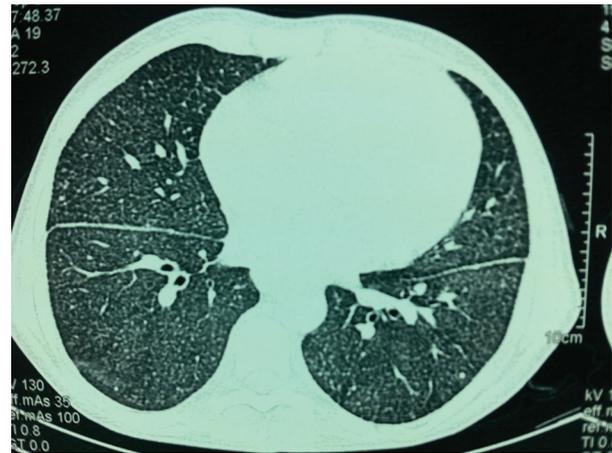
High resolution computed tomography of the chest demonstrated diffuse reticulo-nodular pattern.
